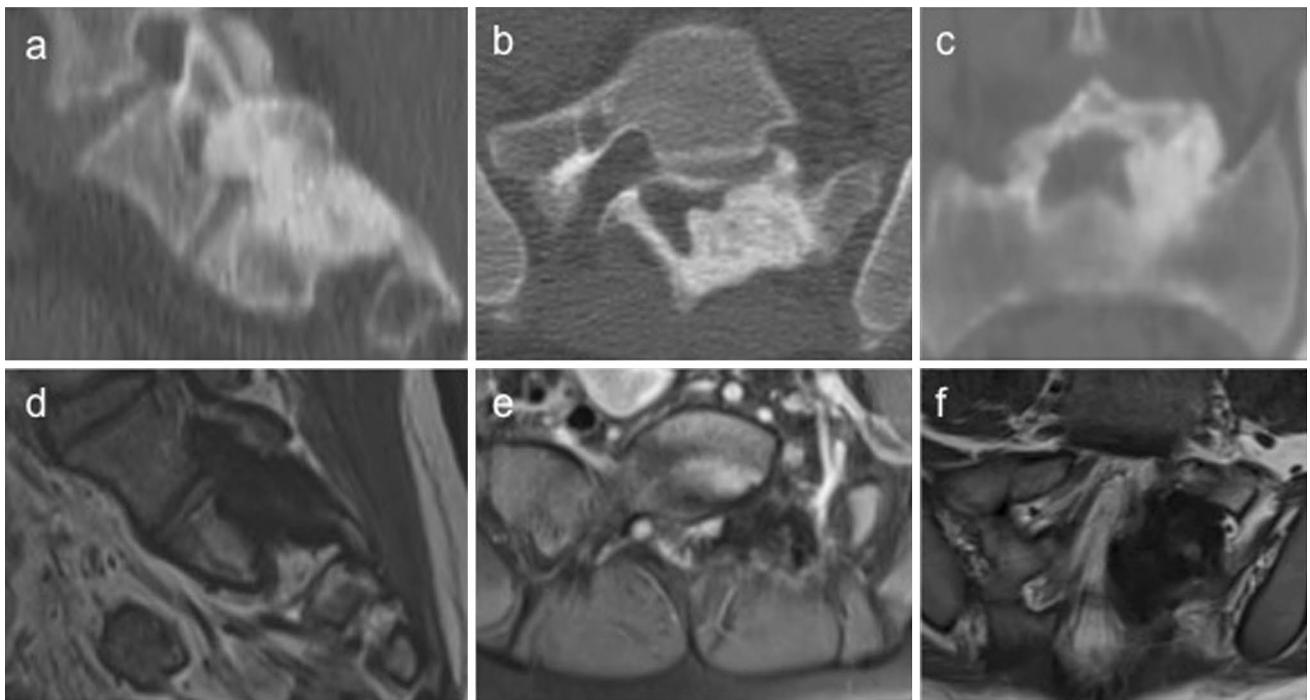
Sagittal (a), axial (b) and coronal (c) CT scan and reciprocal T1-weighted MRI (d–f) images 2 months after denosumab therapy
